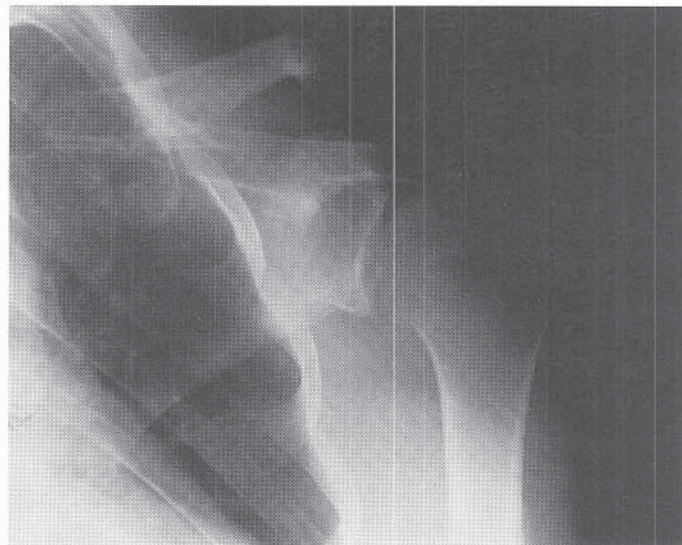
A, The standard chest x-ray technique produces an oblique view of the scapula. B, Orientation of beam to obtain a true AP radiograph of the scapula. C, Scapula as seen on a chest film. D, AP radiograph of the scapula. Compare with oblique view in C. Fractures are more likely to be missed on the oblique projection.
